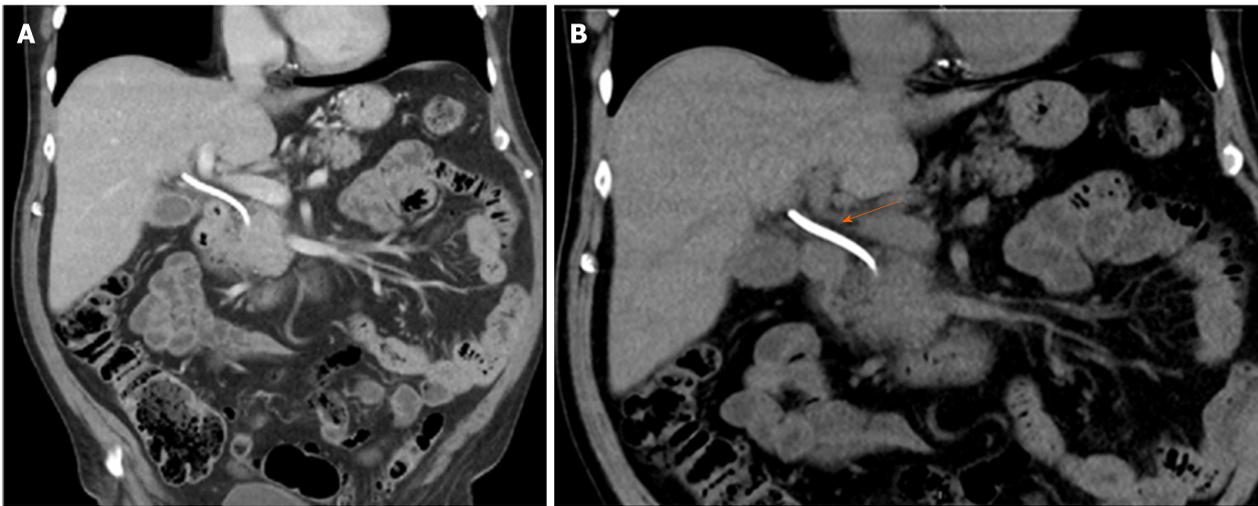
Coronal projection of the preoperative abdominal computed tomography scan. A: The pancreatic head tumor can be appreciated; B: Orange arrow showing the plastic stent placed in the bile duct before referral.
